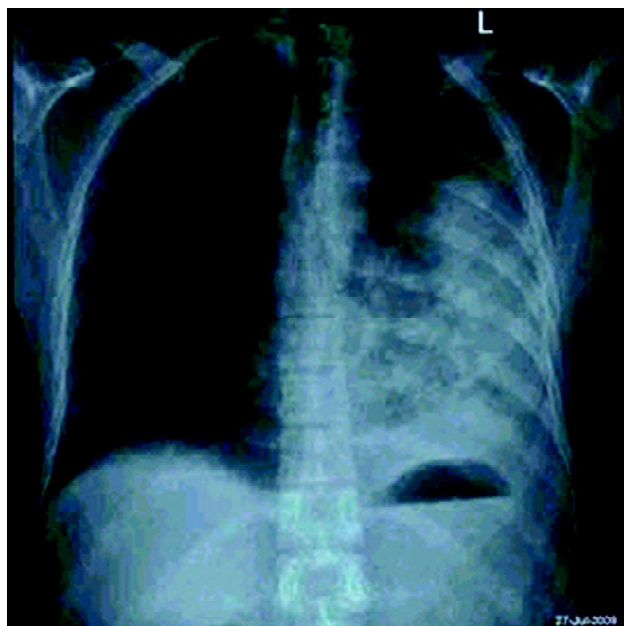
Chest X-ray done after five days shows consolidation in the left middle and lower zones with slight collapse. There is blunting of left C-P angle.
